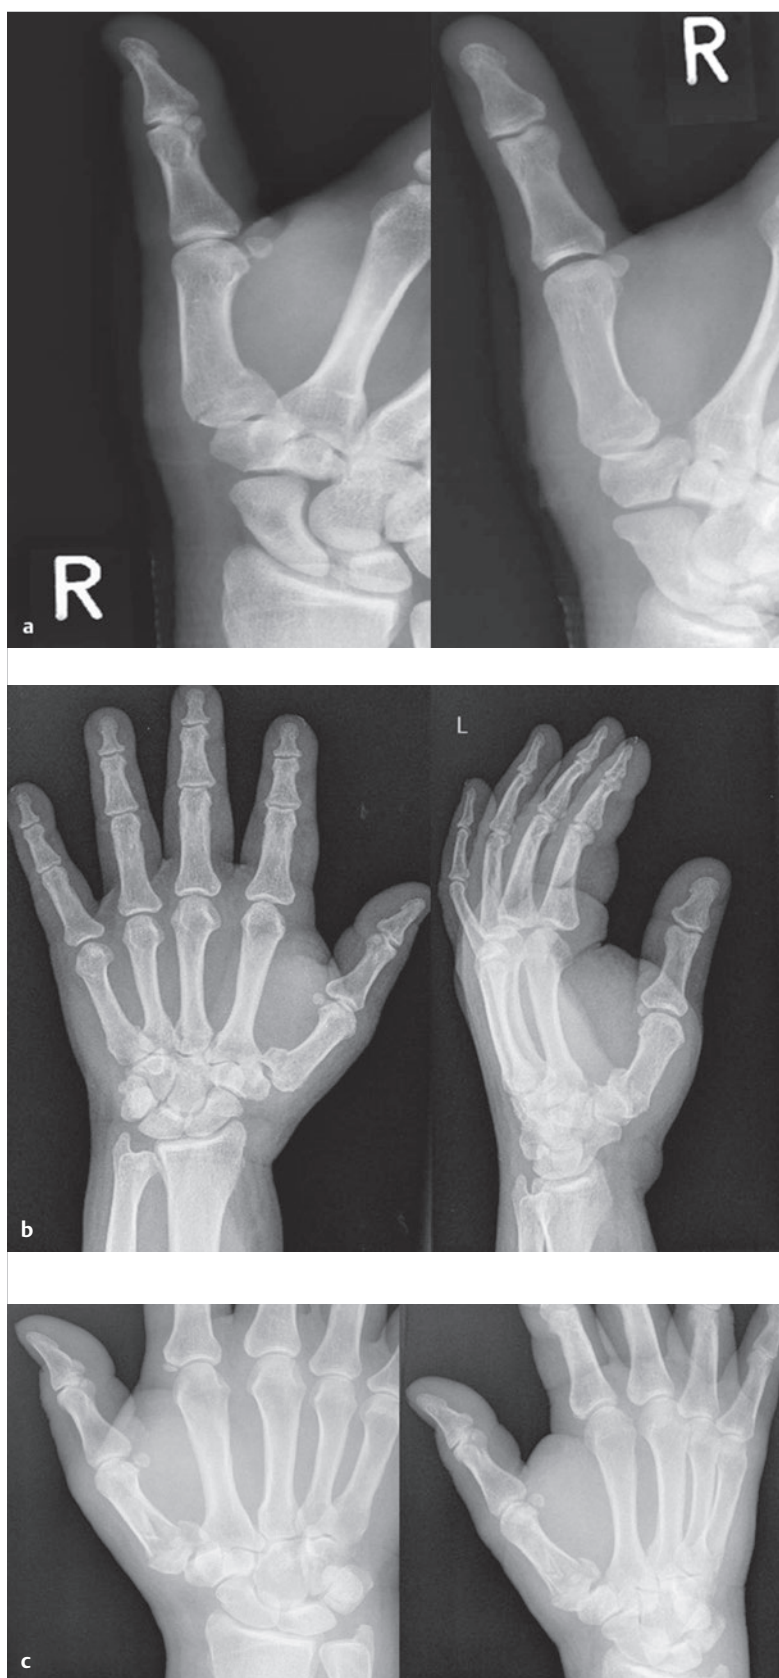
Radiographs of different types of fracture to the base of the thumb. (a) Winterstein's fracture. (b) Bennett's fracture. (c) Rolando's fracture.
